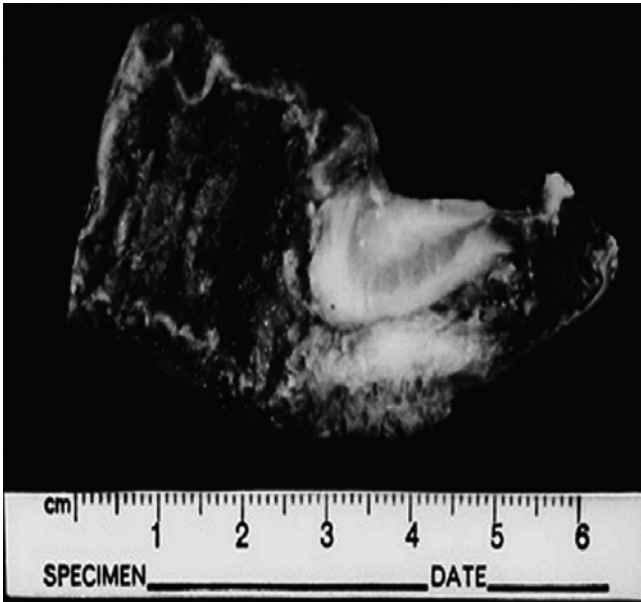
Intestinal fibromatosis. Congenital solitary intestinal fibromatosis (With kind permission from Numanoglu et al. [28]). Review For an overview of the role of imaging, particularly MRI in fibromatosis (see Laffan et al. (2009))
